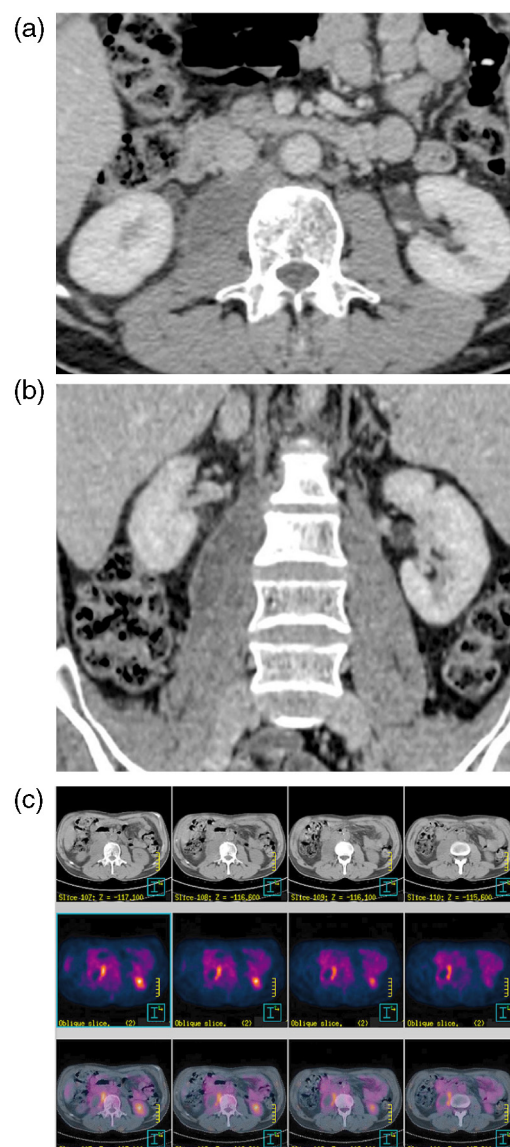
(a, b) CT demonstrating a large residual mass involving right retroperitoneal nodes, the psoas muscle and the vertebral body of L2. (c) PET/CT clearly shows uptake of ^{18}F -FDG in the mass indicating probable residual active disease after treatment.
